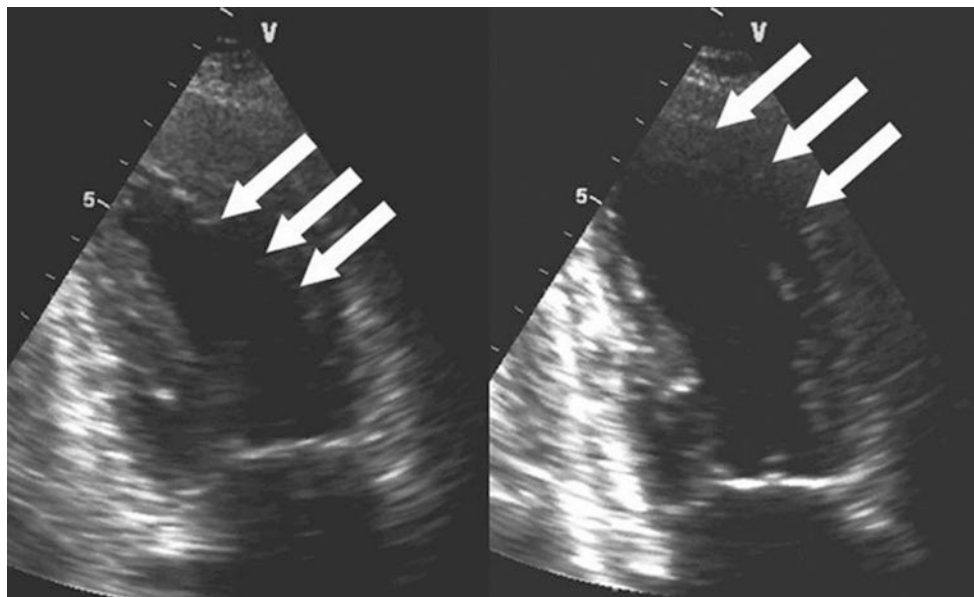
Stress echocardiography demonstrates inducible anterior ischemia in this patient with multivessel coronary artery disease (CAD) including a severe stenosis of the left anterior descending. *Left*, baseline
